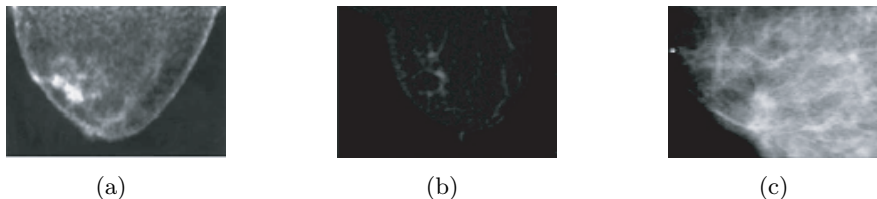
Image of DCIS obtained with the PEM Flex scanner a), with MRI b) and with mammography c). Neither MRI nor mammography could detect the DCIS lesion seen in the PEM image. From[48].
